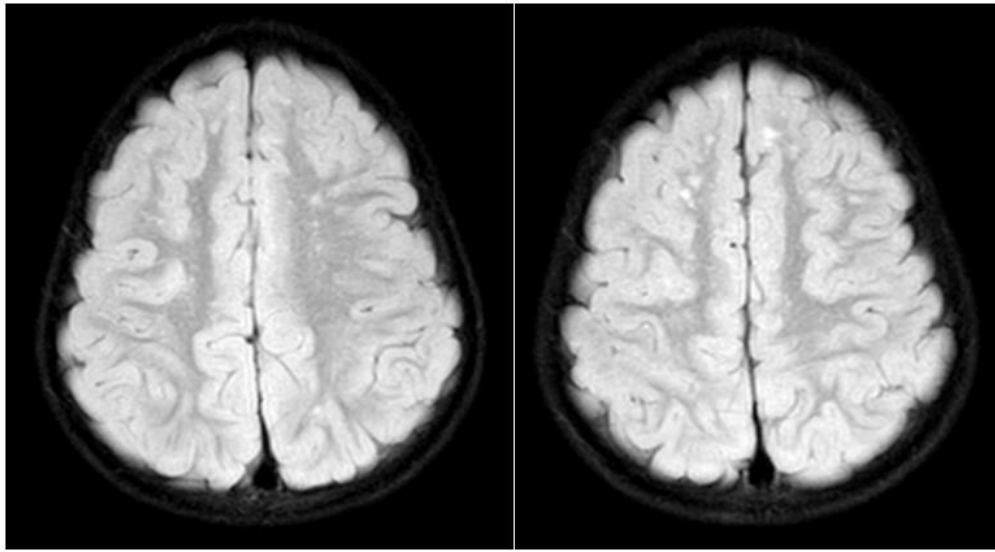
MRI brain reported several T2/FLAIR hyperintense foci at subcortical white matter probably non-specific white matter change
